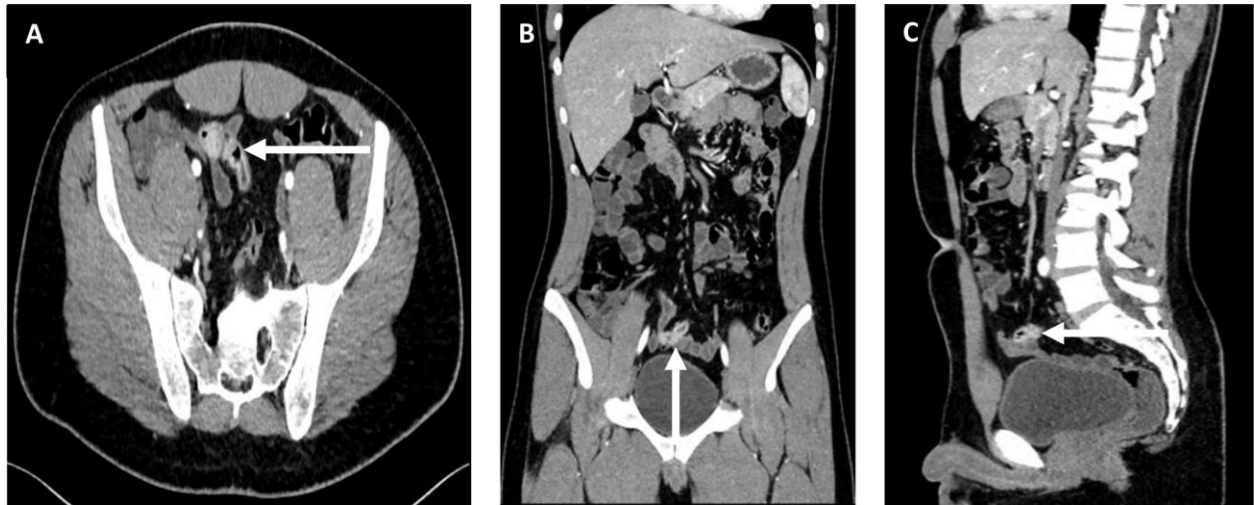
CT abdominal pelvic late arterial phase . (A) an axial view (B) coronal view and (C) Sagittal view. A Focal blind ended tubular stricture form the distal ileal loop (*horizontal arrow*) and (*Vertical arrow*), which is measured 2.3 x 1.3 cm.
